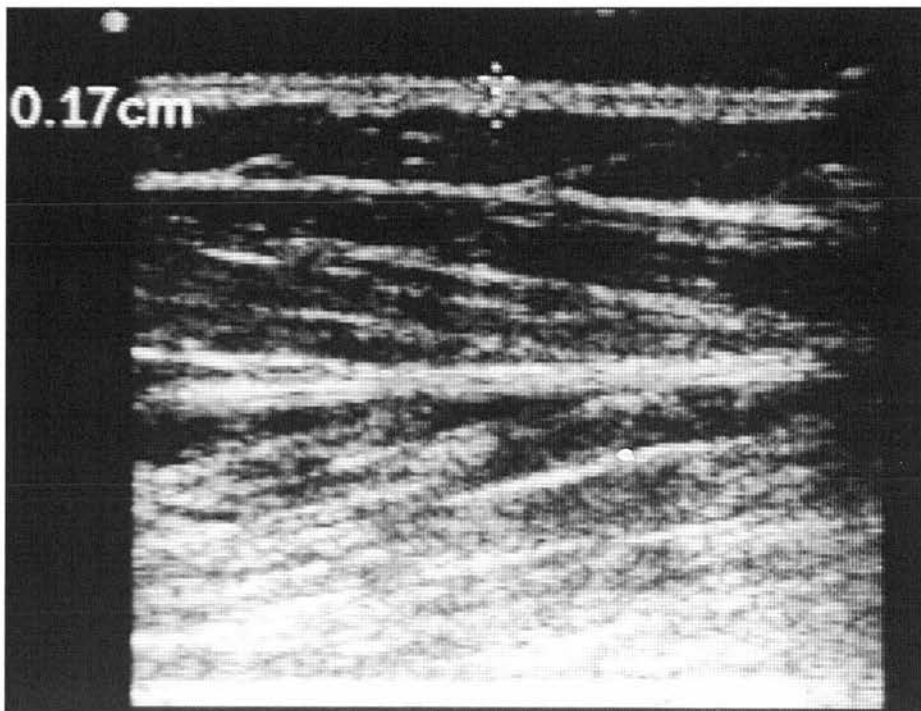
Ultrasound image of the anterior compartment of the leg indicating the resolution of the scan to allow measurement of the skin thickness (cm).
